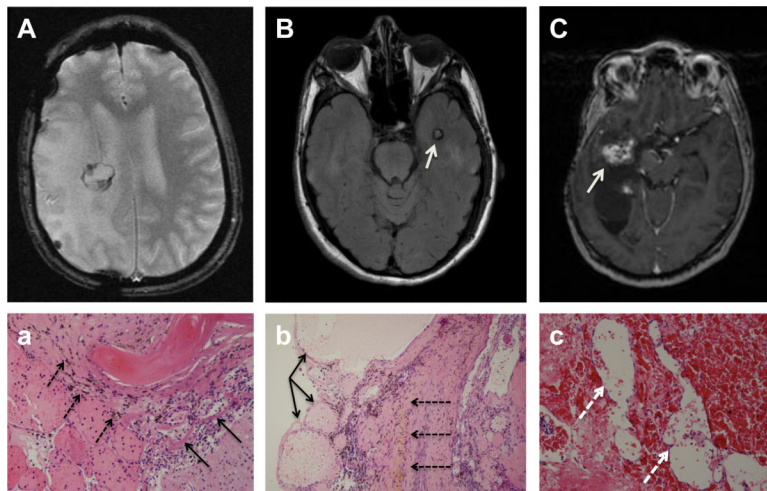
MRI images of three patients who underwent surgical resection for symptomatic ICMs and the corresponding pathology. MRI images of radiographically identified ICMs are shown in A+C. A (Patient 4): T2*-weighted, B (Patient 5): T2 FLAIR, C (Patient 10): T1-weighted MRI. A and B depict the typical appearance of ICM (white arrow) on MRI with a core of mixed increased and decreased signal intensity surrounded by low signal intensity from adjacent hemosiderin-laden parenchyma. Corresponding pathology (a,b) showing classic ICM with abnormal thin walled, dilated non-arterial blood vessels (black thin arrows) with little to no intervening brain tissue surrounded by a rim of hemosiderin-laden macrophages (black dashed arrows) in the adjacent parenchyma. C shows a right temporal-parietal ICM (white arrow) with high signal intensity and (c) corresponding pathology with dilated capillary-like vascular spaces (white dashed arrows) separated by intervening tissue.
